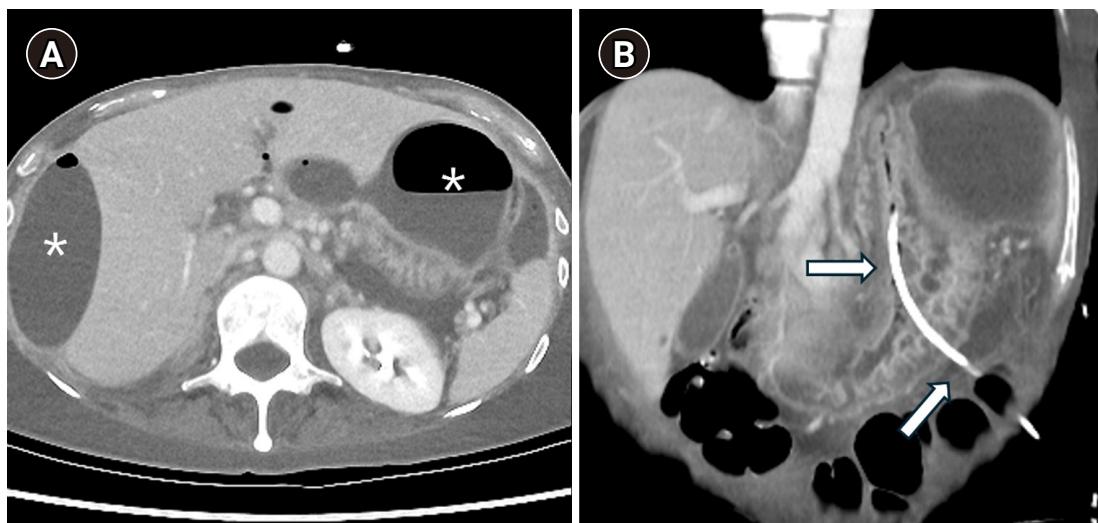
A 53-year-old woman with a history of adhesiolysis for ileus presented with fever and abdominal pain. (A) Axial CT image shows multiloculated intraperitoneal fluid collections requiring drainage (asterisks). (B) Coronal CT image shows a percutaneous drainage catheter inadvertently placed within the stomach (arrows).
